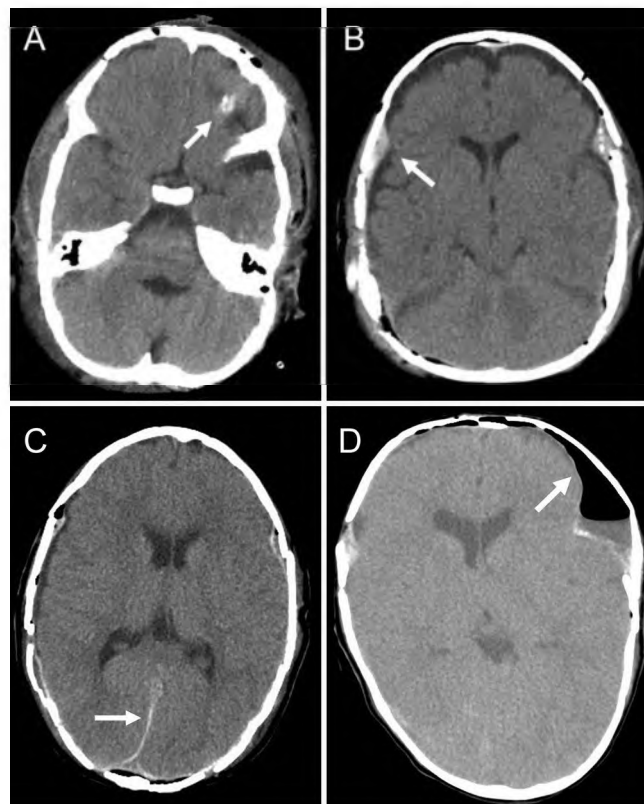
Axial CT scans without contrast enhancement obtained from four patients on postoperative Day 1 after craniosynostosis surgery, demonstrating typical findings that generally lack clinical significance. A: Intraparenchymal contusion without mass effect (arrow). B: Epidural blood (arrow) along the sphenoid ridge and pneumocephalus (a common finding in all the patients). C: Subdural blood along the posterior interhemispheric falx without mass effect (arrow). D: Pneumocephalus with mass effect (arrow).
